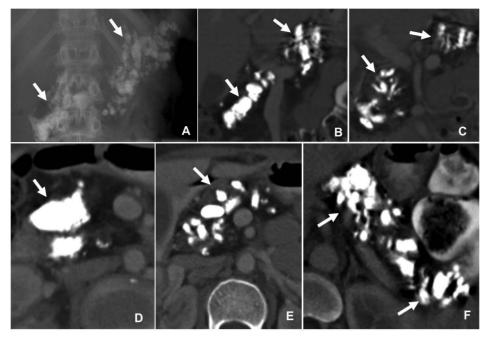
A 20-year-old male patient with tropical chronic pancreatitis (TCP) and diabetes mellitus. Plain radiograph (A), coronal (B, C) and axial (D–F) contrast computed tomography (CT) images show atrophic pancreas and uniform sized large intraductal calculi distributed throughout the pancreas (A–F, arrow).
